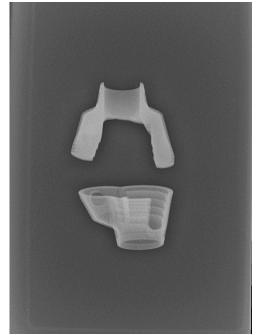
X-ray scan of just the cones submerged in water 81kv and 3.2 mAs
